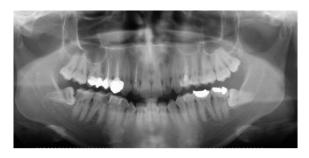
Large periapical lesion in tooth number 22.
